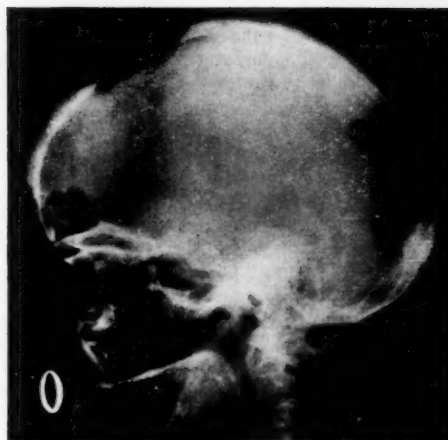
Radiograph showing osteoclastoma of skull
